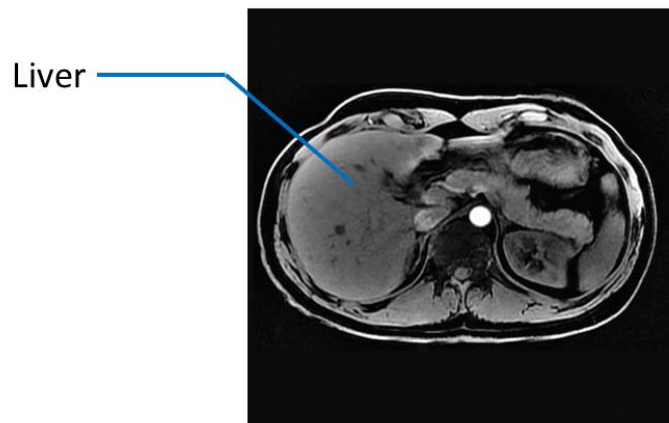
Magnetic resonance image of the abdomen cross-section [127]
